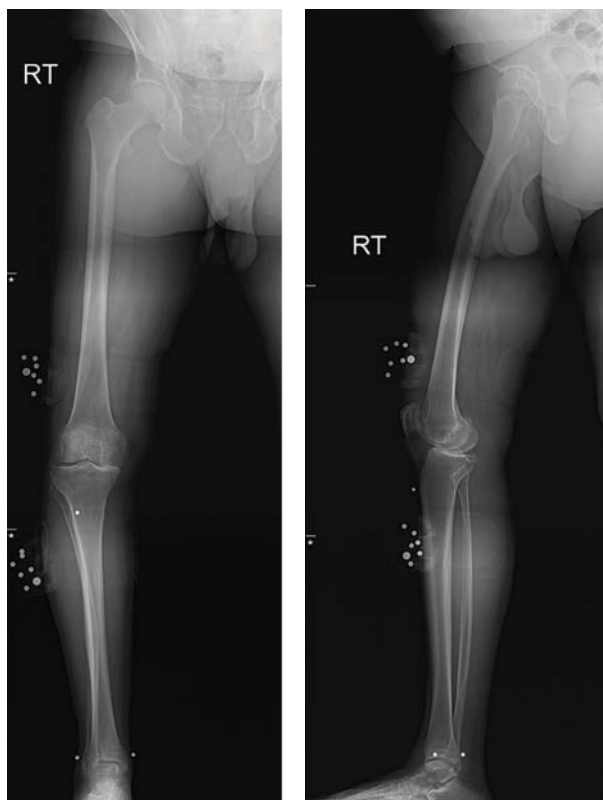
Example of good X-rays
